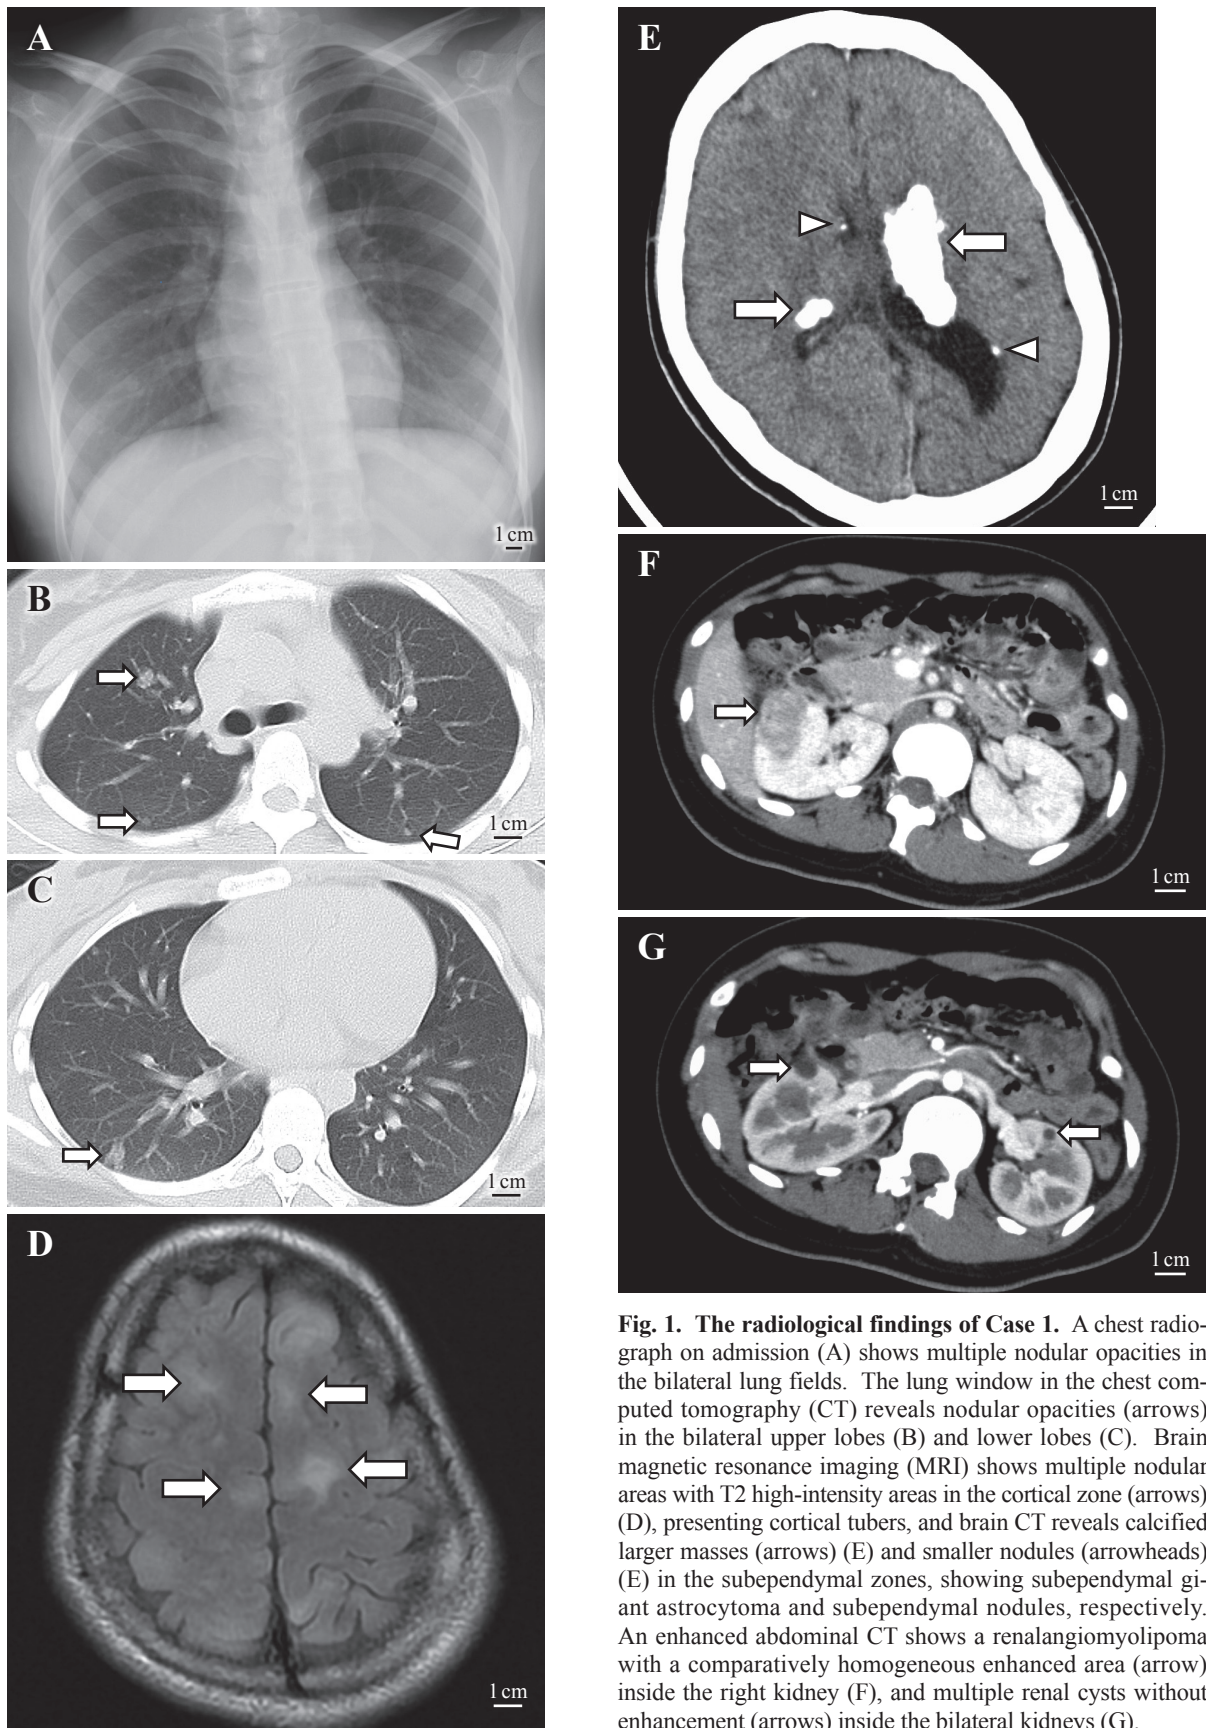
The radiological findings of Case 1. A chest radiograph on admission (A) shows multiple nodular opacities in the bilateral lung fields. The lung window in the chest computed tomography (CT) reveals nodular opacities (arrows) in the bilateral upper lobes (B) and lower lobes (C). Brain magnetic resonance imaging (MRI) shows multiple nodular areas with T2 high-intensity areas in the cortical zone (arrows) (D), presenting cortical tubers, and brain CT reveals calcified larger masses (arrows) (E) and smaller nodules (arrowheads) (E) in the subependymal zones, showing subependymal giant astrocytoma and subependymal nodules, respectively. An enhanced abdominal CT shows a renalangiomyolipoma with a comparatively homogeneous enhanced area (arrow) inside the right kidney (F), and multiple renal cysts without enhancement (arrows) inside the bilateral kidneys (G).
